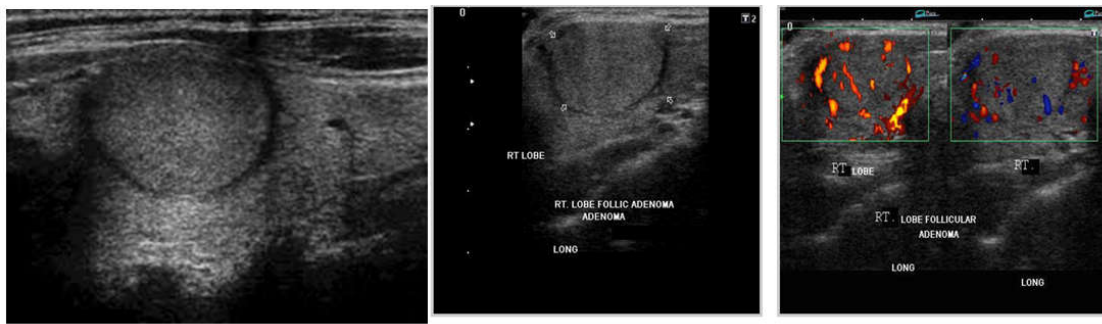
US, power and color doppler, of follicular adenoma in the rt. Lobe ,note the peripheral sonolucent "halo"
